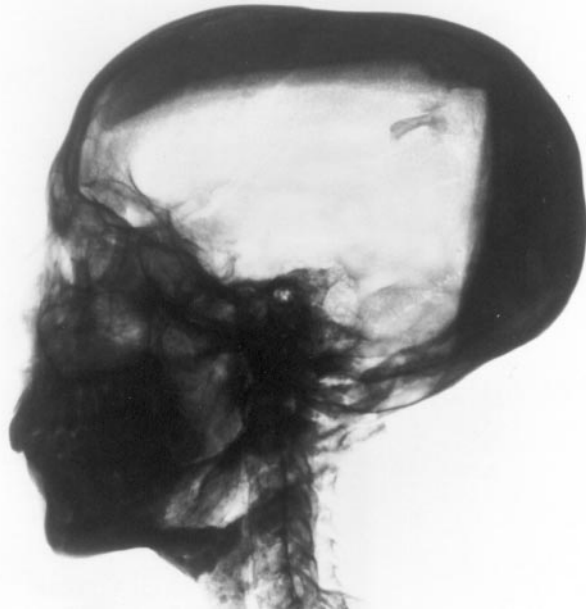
Lateral view radiograph of Tutankhamen's skull and cervical spine with contrast reversed. Intracranial fragments are more conspicuous than on the white on black images. (Reprinted courtesy of the University of Liverpool.)
